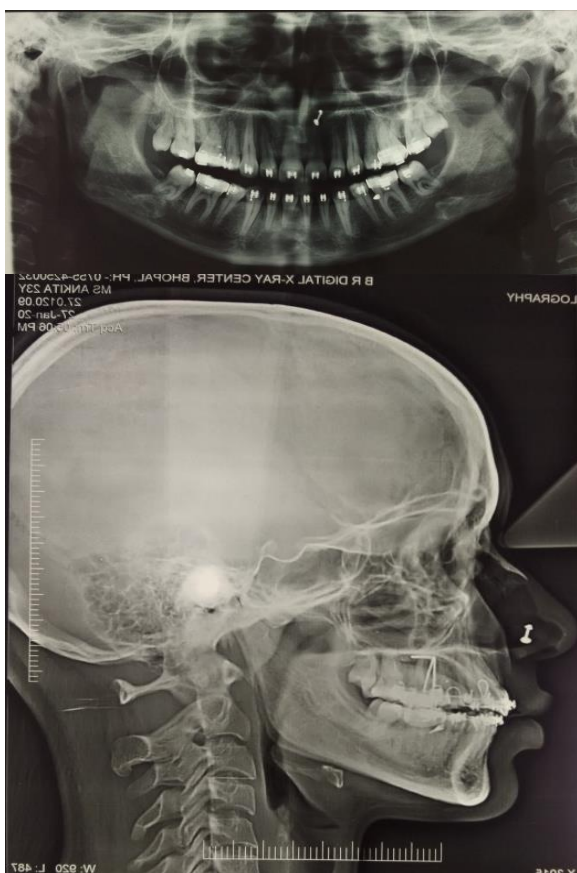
Demonstrates the lateral cephalogram and orthopantomogram following the retraction of the anterior teeth and protraction of third molars into the position of the second molars in the mandibular arch.
